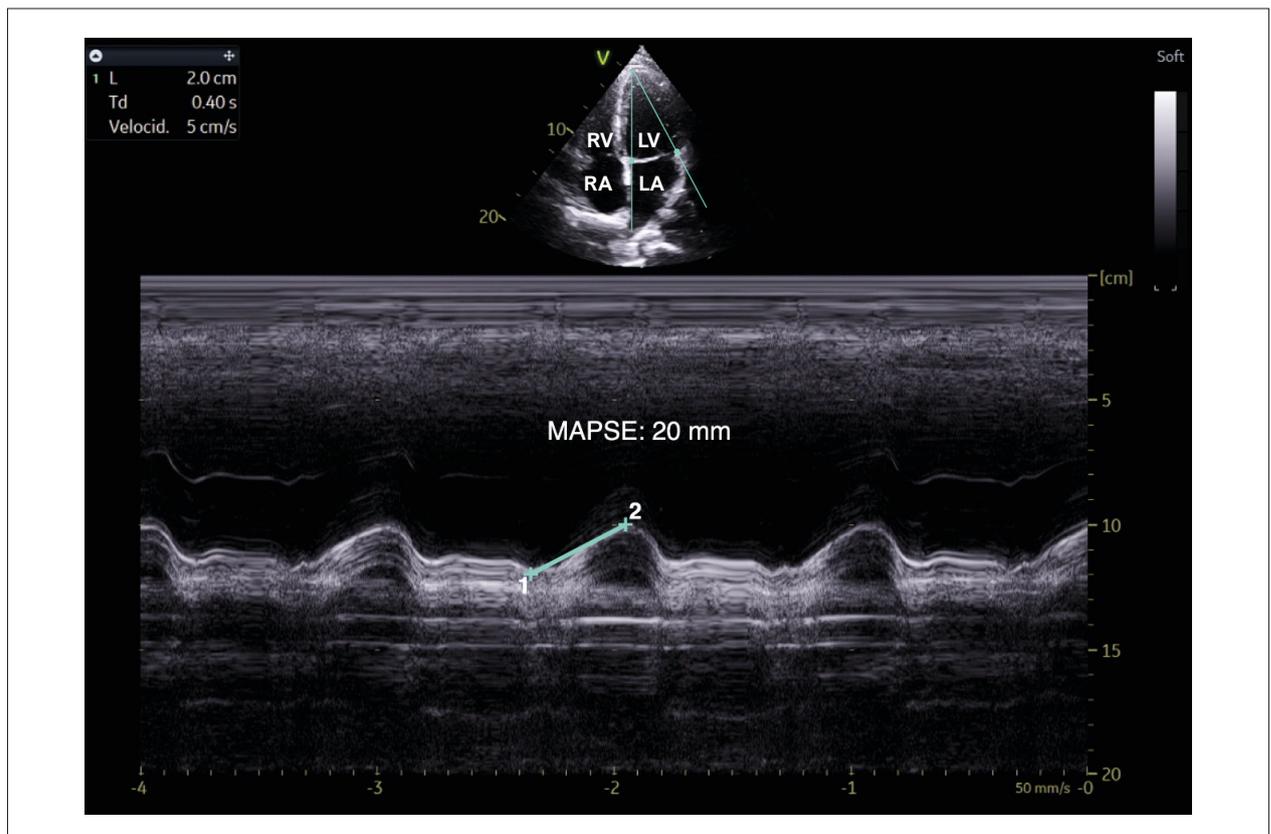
MAPSE calculated from M-mode in 2D echocardiography in an athlete patient, obtaining a value of 20 mm, considered normal. Source: created by the authors. RV: right ventricle; LV: left ventricle; RA: right atrium; LA: left atrium; MAPSE: mitral annular plane systolic excursion.
